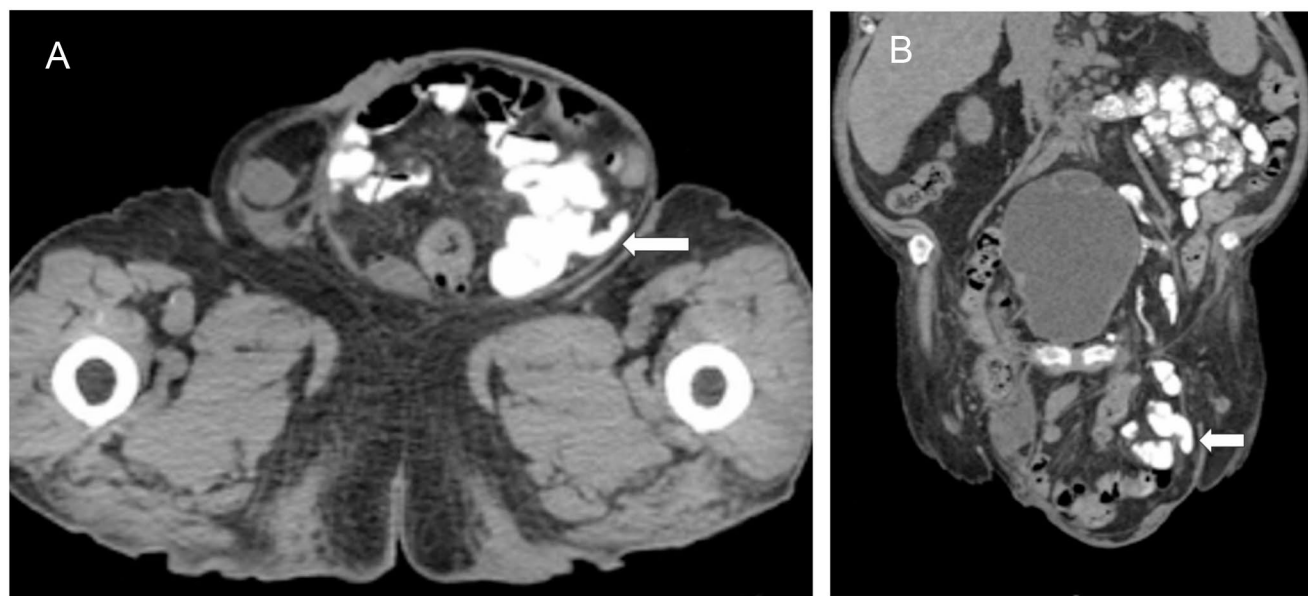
A Axial section of the groin area from the abdominal and pelvic CT with oral contrast in this 74-year-old man reveals the opacified ileal loops with a 3 cm long Meckel's diverticulum (arrow) within the left
